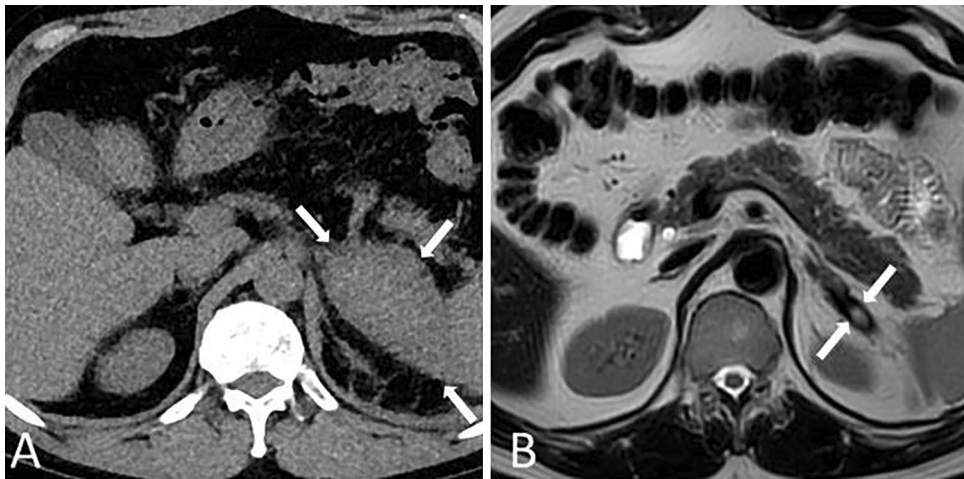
44-year-old male patient with no known past medical history presents with acute onset left upper quadrant pain. A Axial unenhanced CT image shows a hyperdense mass in the left adrenal gland (arrows) with associating periadrenal fat stranding. No discernible enhancement was seen on postcontrast images (not shown). The lesion represented either a ruptured mass or an idiopathic adrenal
